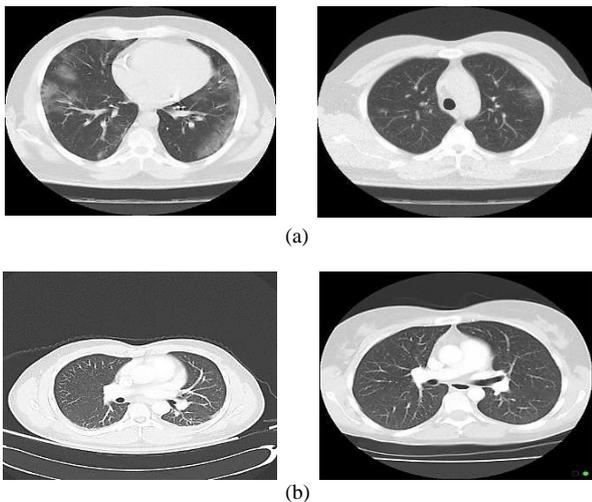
(a) Sample of CT scan images SARS-CoV-2 infected; (b) sample of CT scan images of healthy condition.
